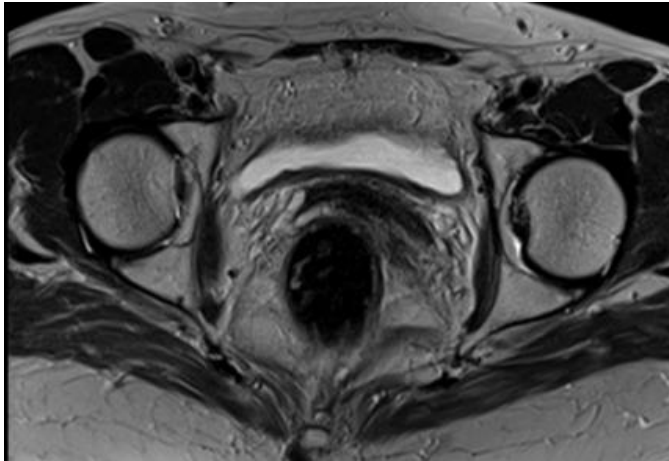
Magnetic resonance imaging of the pelvis after chemoradiotherapy of rectal cancer, in axial T2w sequence demonstrating complete regression of rectal tumor
